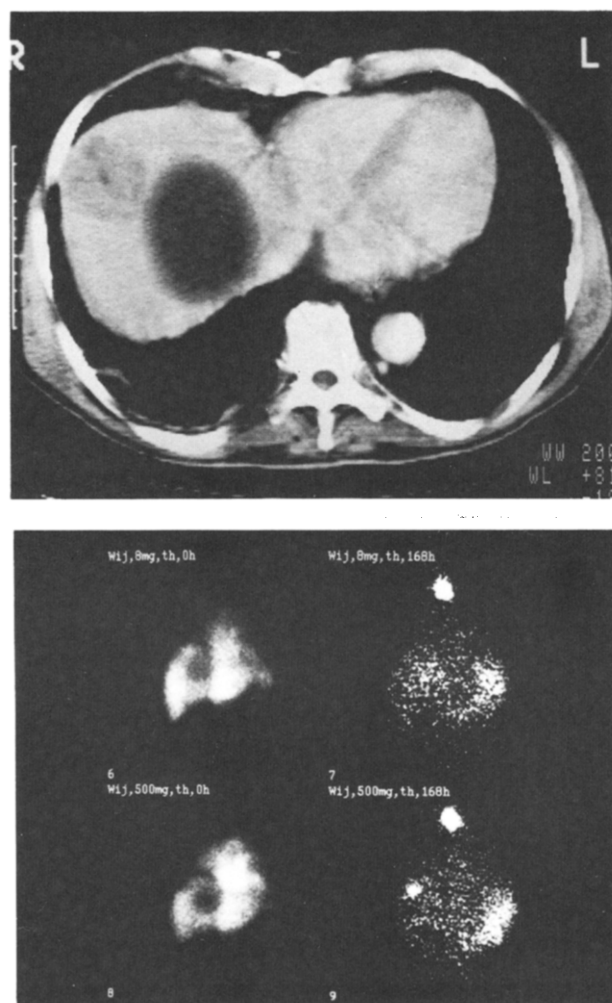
Patient III-5 had cysts in the liver. Adjacent to the large cyst in the right liver lobe was a metastasis with a diameter of 5 cm (upper); immunoscintigraphy of the liver area at day 7 showed uptake in the cyst at the time of the first infusion with ^{131}I -16.88 (8 mg), whereas after the second infusion (with addition of 500 mg unlabelled 16.88) clear visualisation was obtained of the metastasis (lower). Immunoscintigrams at day 7 also show uptake in the thyroid and in the stomach.
